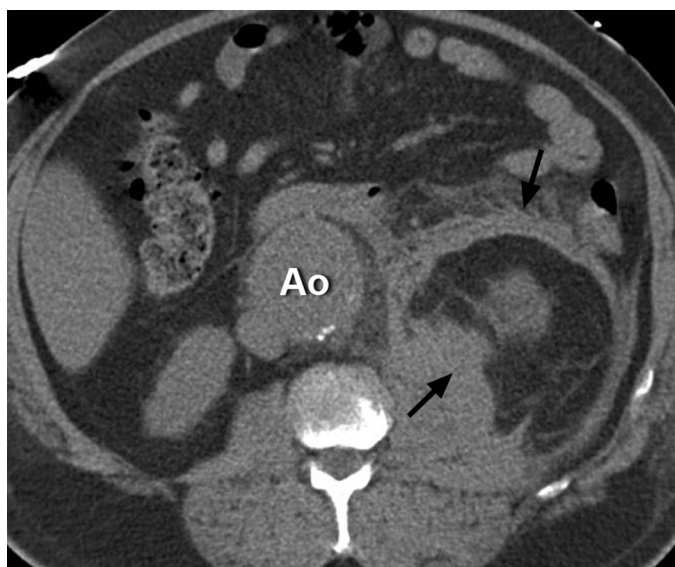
FIGURE e57-3 Non-contrast-enhanced CT demonstrating rupture and hemorrhage (*arrows*) from a descending thoracoabdominal aortic aneurysm (Ao).
